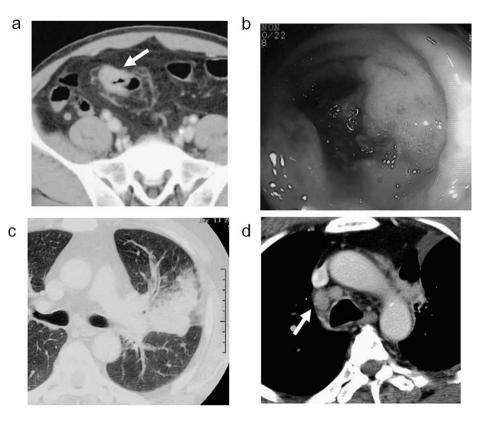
Computed tomography (CT) scan (a) and endoscopic findings (b) of primary tumor. Left lung metastasis was detected in 2004 (c) and the mediastinal lymph node metastasis in 2005 (d).
